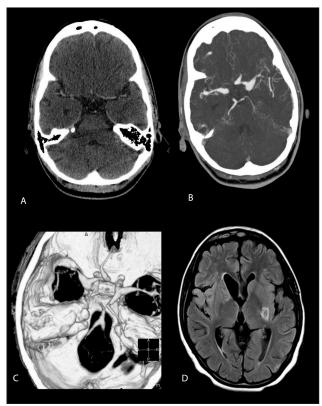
(A) Contrast-enhanced CT brain scan (3/12/2010) at the level of the circle of Willis showing bilateral normal calibre middle cerebral arteries. (B) CT cerebral angiogram (CTA) source image 3D MIP (5/10/2011) demonstrating fusiform aneurysmal dilatation of both right and left middle cerebral arteries and left anterior cerebral artery. (C) Volume-rendered 3D image of the CTA (5/10/2011) showing diffuse fusiform aneurysmal vasculopathy of the circle of Willis, vertebral, basilar and left posterior communicating arteries. (D) MRI FLAIR (TE 114, TR10 000) demonstrating increased signal in the right corpus striatum (with ex vacuo dilatation), insular- and peri-sylvian cortices as well as left posterior globus pallidus.
